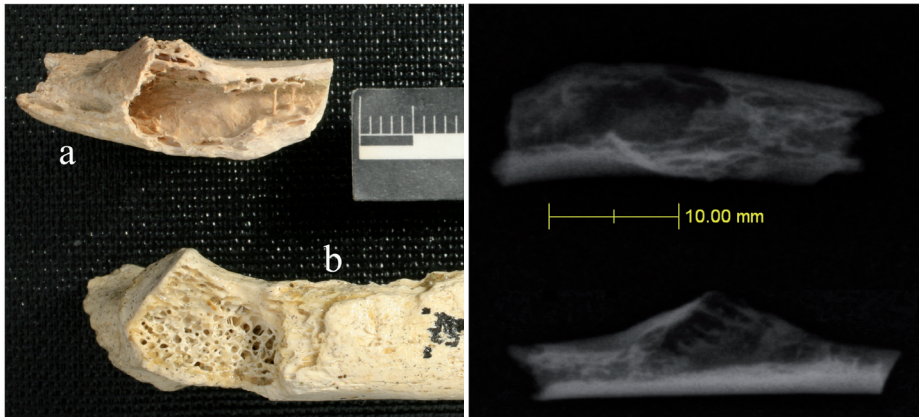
2 Photograph of the ‘first tumor’ in medical history, which was discovered in the right rib of a 120,000+ years old Neanderthal who has lived in what is nowadays Croatia. The photograph clearly shows destruction of trabeculae and involvement of the cortex (a) compared to the normal pattern of bony trabeculae in a left rib from the same collection (b). Conventional radiographs of the rib in a position matching photograph 1.1a show a lesion of approximately 10mm with destruction of bony tissue and a sharp, non-sclerotic margin. Based on these images, the most likely diagnosis is fibrous dysplasia, making it the oldest ‘tumor’ known to mankind. Consent for the use of these images was given by corresponding author David Frayer.
